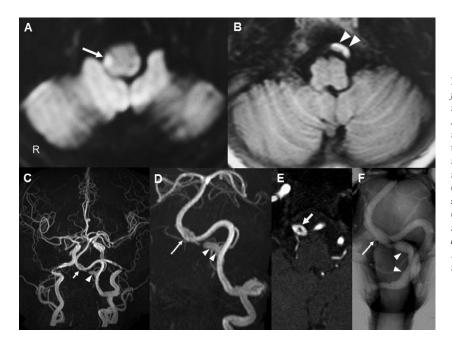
Diffusion-weighted MR imaging (A) performed on admission shows hyperintensity in the right posterolateral medulla (arrow). T1-weighted MR imaging (B), MR angiography (C), and a partial maximum intensity projection image of the vertebrobasilar system (D) show occlusion of the right VA with thrombus in the pseudolumen (arrowheads) and dilation of the proximal basilar artery (BA) (arrow). MR angiographic source image (E) shows a double lumen in the right occluded VA (arrow). Basi-parallel anatomical scanning-MR imaging (F) shows dilatation of the outer contour at the right VA (arrowheads) and the proximal BA (arrow). Abbreviations: MR, magnetic resonance; VA, vertebral artery.
